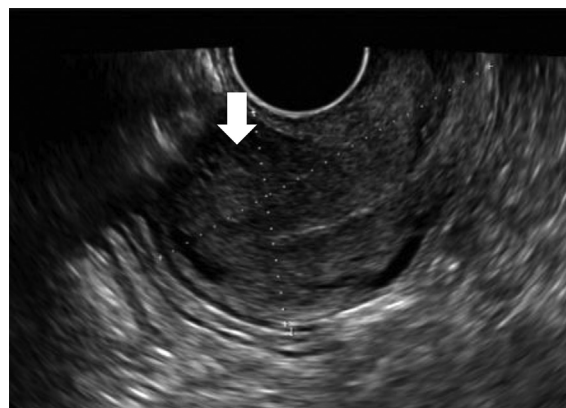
Transvaginal sonography imaging. Hyperechogenic tumor was detected in the fundus of the uterus (arrows).
